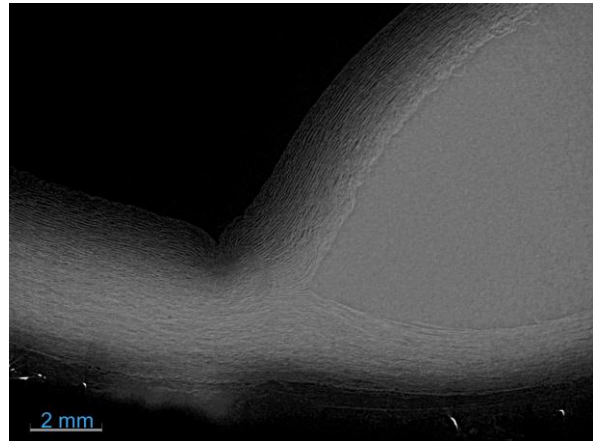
High-resolution s-CT image of post-dissected aorta.
